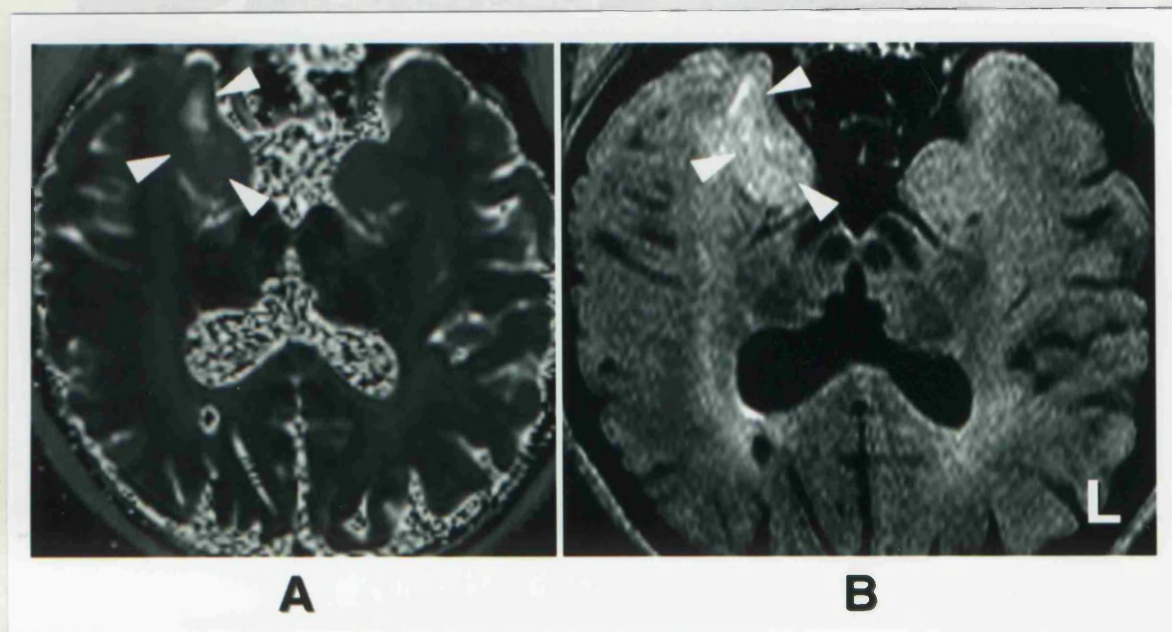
Isolated hyperdense lesion of the amygdala. Patient was a 54 year old man with onset of TLE at the age of 21 years. There was no history of FCs, or meningitis. He had an average of one CPS per month and had a total of four SGS. Interictal EEG showed a clear right antero-temporal epileptic focus. Standard MRIs were all reported as normal. Hippocampal quantitation was normal: HCT2 right = 108 msec, HCT2 left = 104 msec (NI: ≤ 108 msec), HCVR (R/L) = 0.99 (NI: ≥ 0.87), HCV right = 5018 mm³, HCV left = 5079 mm³ (NI: ≥ 4348 mm³). On visual inspection of the AT2 map (A), there was an increased T2 signal throughout the right amygdala, and a triangular shaped region of increased T2 signal anterior to the right amygdala (white arrows). The AT2 on the right was 113 msec, and on the left was 100 msec (NI: ≤ 104 msec). The FLAIR image (B) confirmed that this increased T2 signal was not due to CSF, but due to tissue changes in this region (white arrows). [Hospital number: QSA77724].
